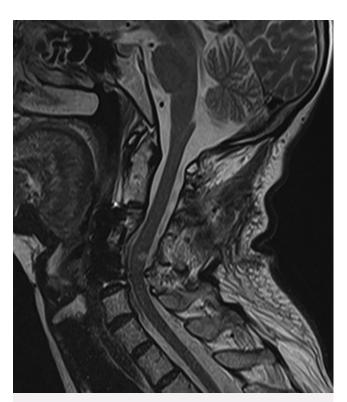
Postoperative sagittal T2-weighted MR image of the cervical spine obtained 5 months after surgeries, showing regression of the previously observed hyperintense region of the spinal cord.
